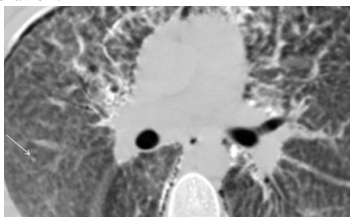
axial CT scan with thin sections in lung window showing tiny air space nodules of which density is varying from soft tissue to calcific HU (white arrow).
